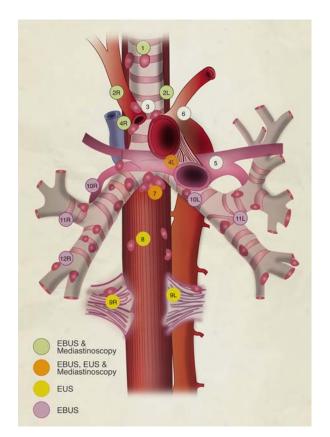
Lymph node map adapted from the 2009 IASLC classification. The colors demonstrate the lymph nodes that can traditionally be reached by EBUS, mediastinoscopy, and EUS. The area of lymph node 5 and 6 are traditionally considered to be out of the reach of all of these methods. EBUS indicates endobronchial ultrasound.
